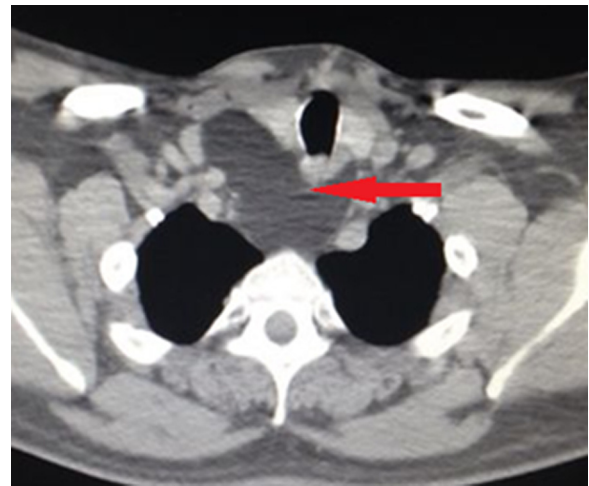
CT showing the extent of the lesion in both upper mediastinum and towards both supraclavicular regions.
